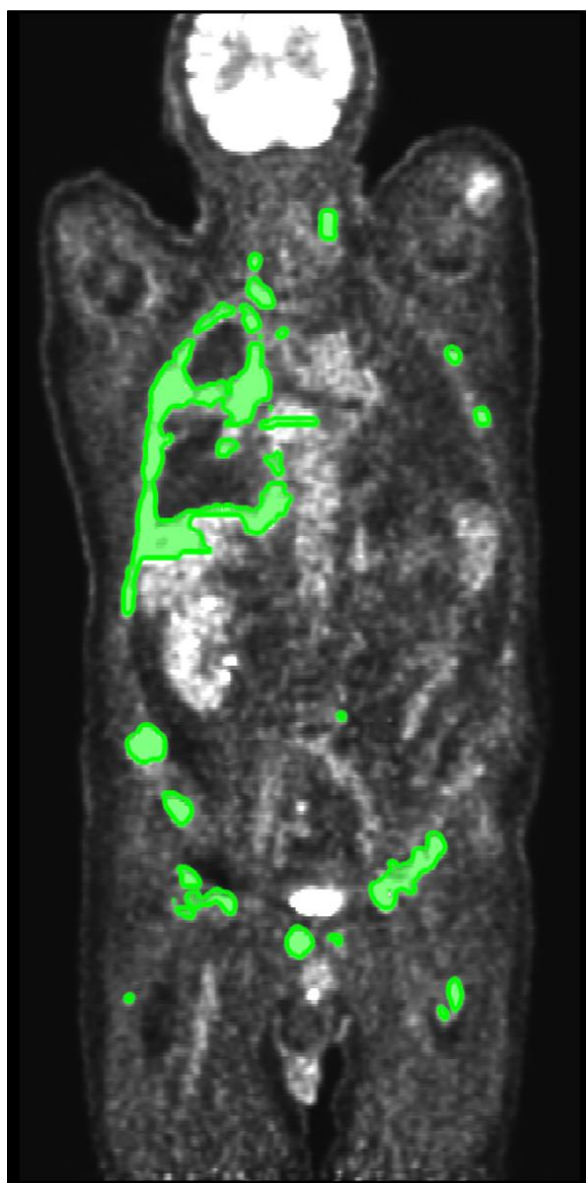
Manual segmentation of FDG-avid malignant lesions
